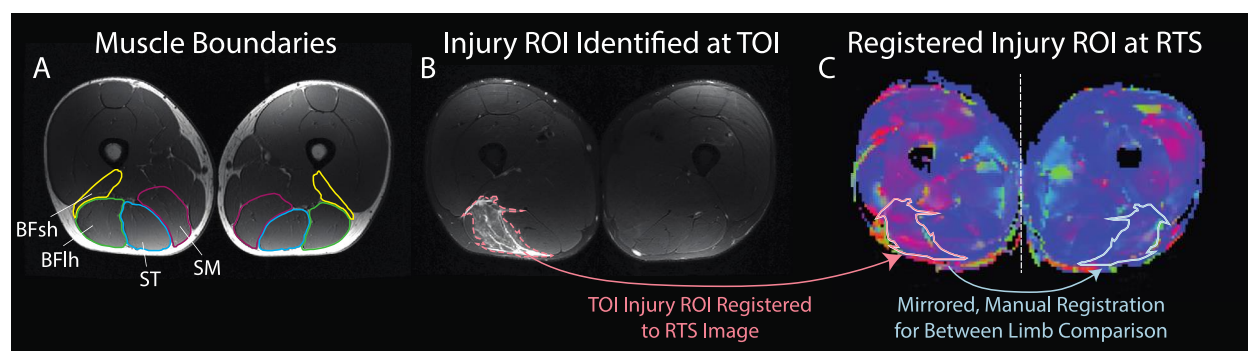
Mean quantitative diffusion metrics were calculated within manually outlined regions of injury (ROI) on the injured limb defined by the hyperintense region of signal on T2-weighted imaging at the time of injury (TOI). Injury ROIs were registered to follow up scans at return to sport (RTS) (peach arrow). For between limb comparisons, ROIs were mirrored and manually registered to the uninvolved limb (white arrow). Data shown are from one slice of a representative participant. Biceps femoris short head (BFsh), biceps femoris long head (BFh), semitendinosus (ST), semimembranosus (SM).
